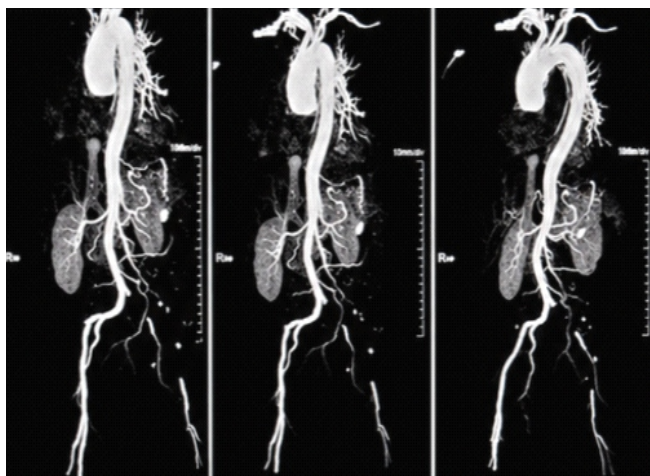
CT aortogram showing multifocal arterial thrombosis involving the abdominal aorta and iliac arterial system, with complete left iliac artery thrombosis and reduced distal peripheral vascular opacification, suggestive of a hypercoagulable thromboembolic state.
